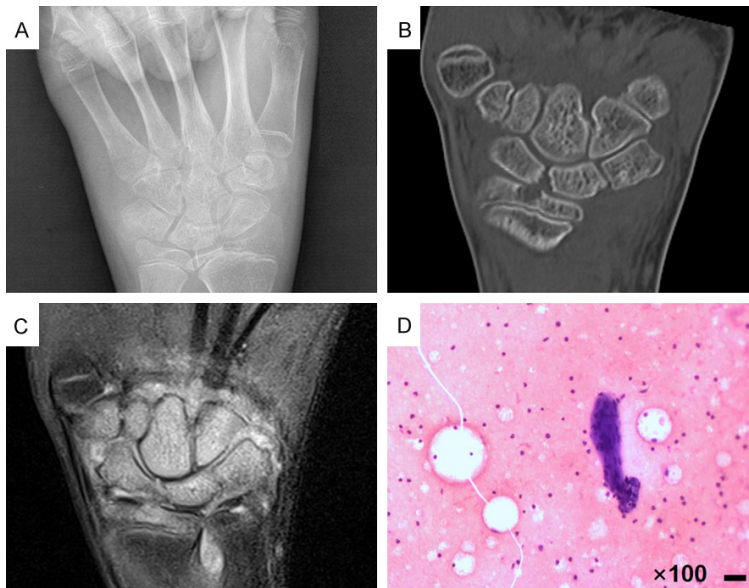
Anteroposterior radiograph (A) and CT image (B) of the left wrist demonstrated multiple bone destruction foci; (C) MRI of the left wrist showed multiple abnormal signal shadows and arthroedema; (D) Cytologic examination indicated a few short spindle cells and inflammatory cells in the swelling of the left wrist. Scale bar, 200 µm. Magnification, 100 ×.
